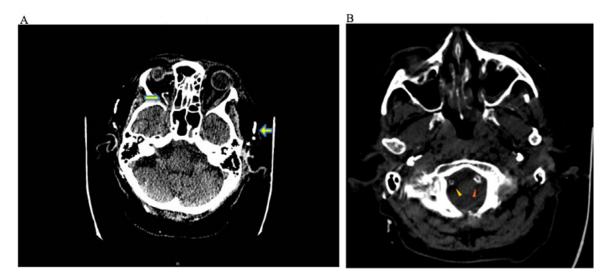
Plain cranial CT scan. (A) Calcification of temporal arteries and of the right ophthalmic artery. (B) Bilateral calcification of the vertebral arteries.
